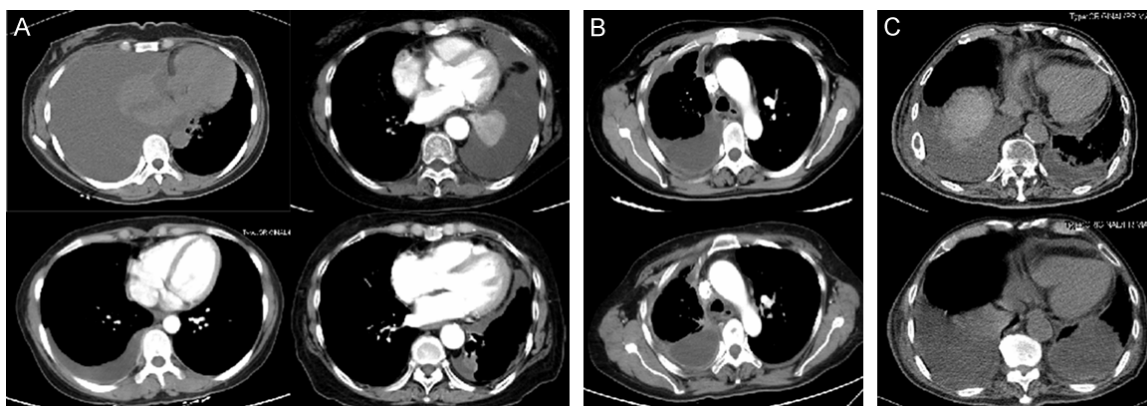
Chest computed tomography scans showed the outcomes of four weeks of treatment. A. Two patients with MPE achieved partial remission (PR) of pleural effusion. B. One MPE patient with stable disease (SD). C. One MPE patient obtained progressive disease (PD) of pleural effusion.
